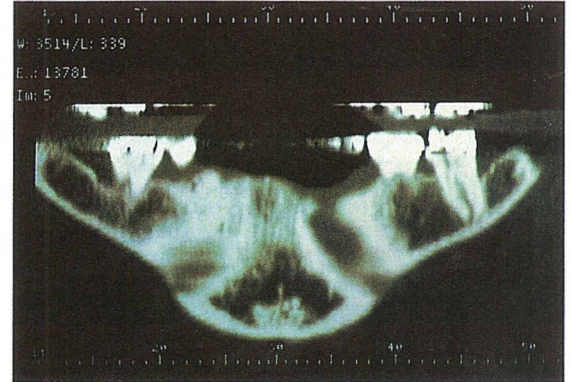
Panoramic radiograph shows a good symphysis area and a narrow crest up to 1 mm.
